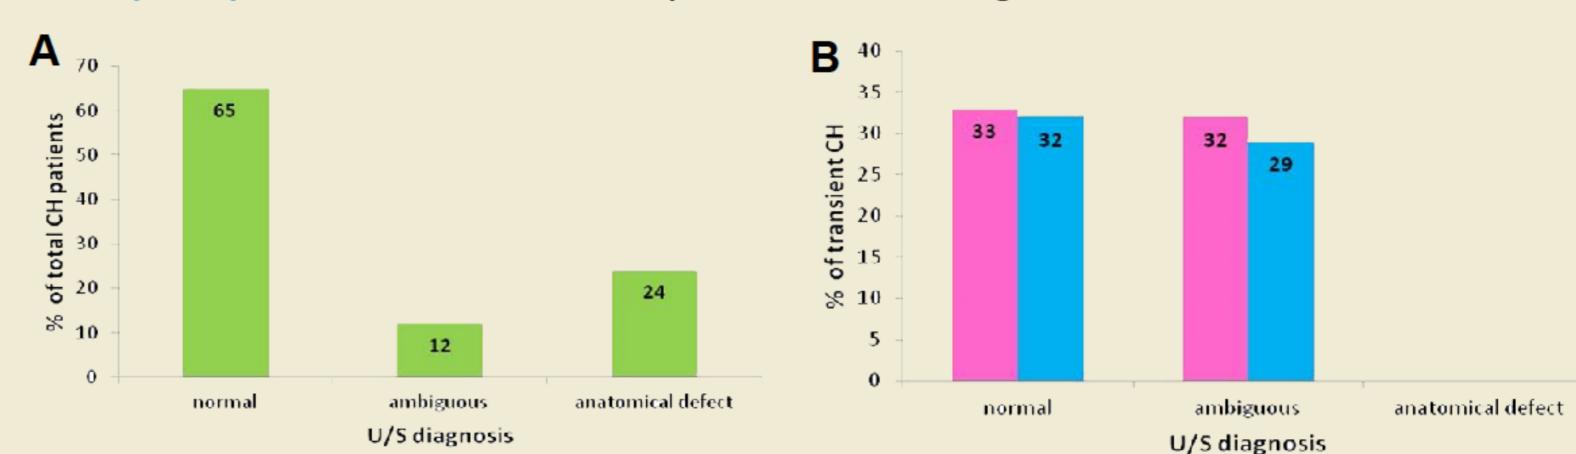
(A) The distribution of CH neonates according to ultrasonographic (U/S) diagnosis (data depicted as percent of total number of patients): in 65% of patients the thyroid gland was considered as normal, in 12% ultrasonographic data were categorized as ambiguous and in 24% anatomical defects were apparent (B) Transient CH (shown as percent within each U/S subgroup) of female (pink) and male (blue) CH neonates with respect to weeks of gestation.
